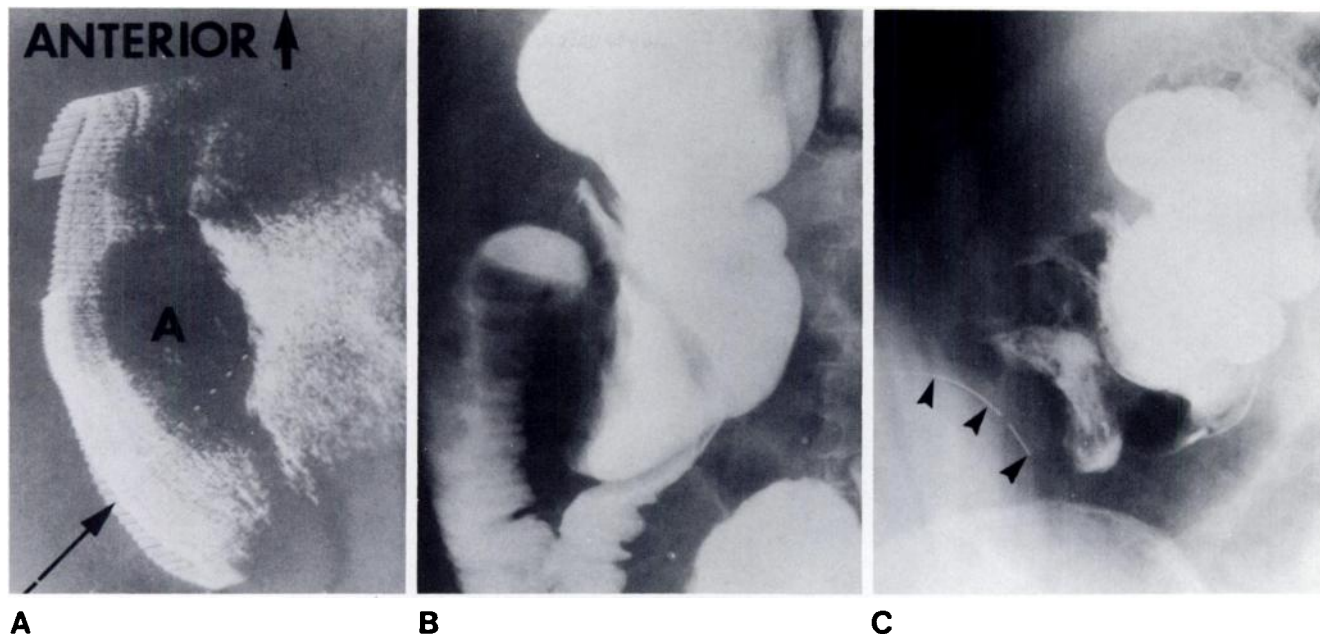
Case 1. A, Sonogram of right flank in transverse plane 2 cm above iliac crest. Oval 5 × 10 cm relatively anechoic abscess (A) 4 cm deep to skin posterolaterally in right lower quadrant. Good through-transmission of ultrasound by homogeneous mass with many low-level internal echoes. Long arrow and sonographic marker demonstrate site and angle of planned drainage route via preferable retroperitoneal pathway. Sonographic markers at 1 cm intervals indicate depth of abscess. B, Barium enema examination. Lateral compression and anteromedial displacement of cecum by extrinsic mass. Appendix not visualized. C, Radiograph immediately after percutaneous drainage. Trocar catheter (arrowheads) in abscess. After initial drainage of 750 ml, there is decreased mass effect on cecum which has returned to normal position.
